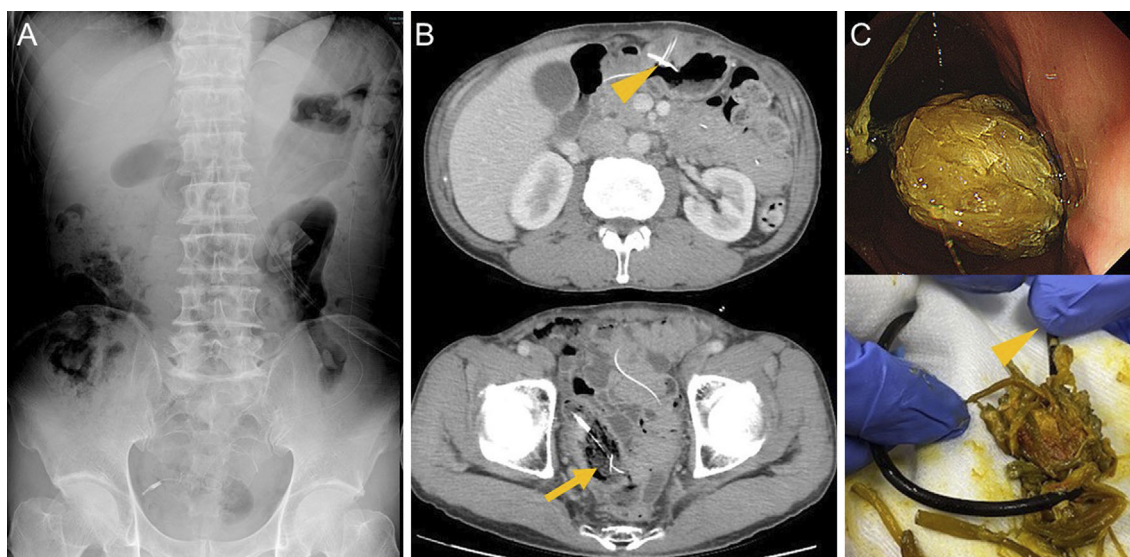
(A) Abdominal radiography shows that the phytobezoar is lodged deep in the pelvic jejunum. (B) Computed tomography shows a hypodense mass containing air in the jejunum at the tip of the J-tube (arrow), and the position of the gastric fixation plate is maintained (arrowhead). (C) Upper gastrointestinal endoscopy shows an entangled undigested vegetable at the knot at the pigtail-shaped of the J-tube, forming a phytobezoar (diameter: 2.5 cm). The arrowhead indicates the tip of the J-tube.
